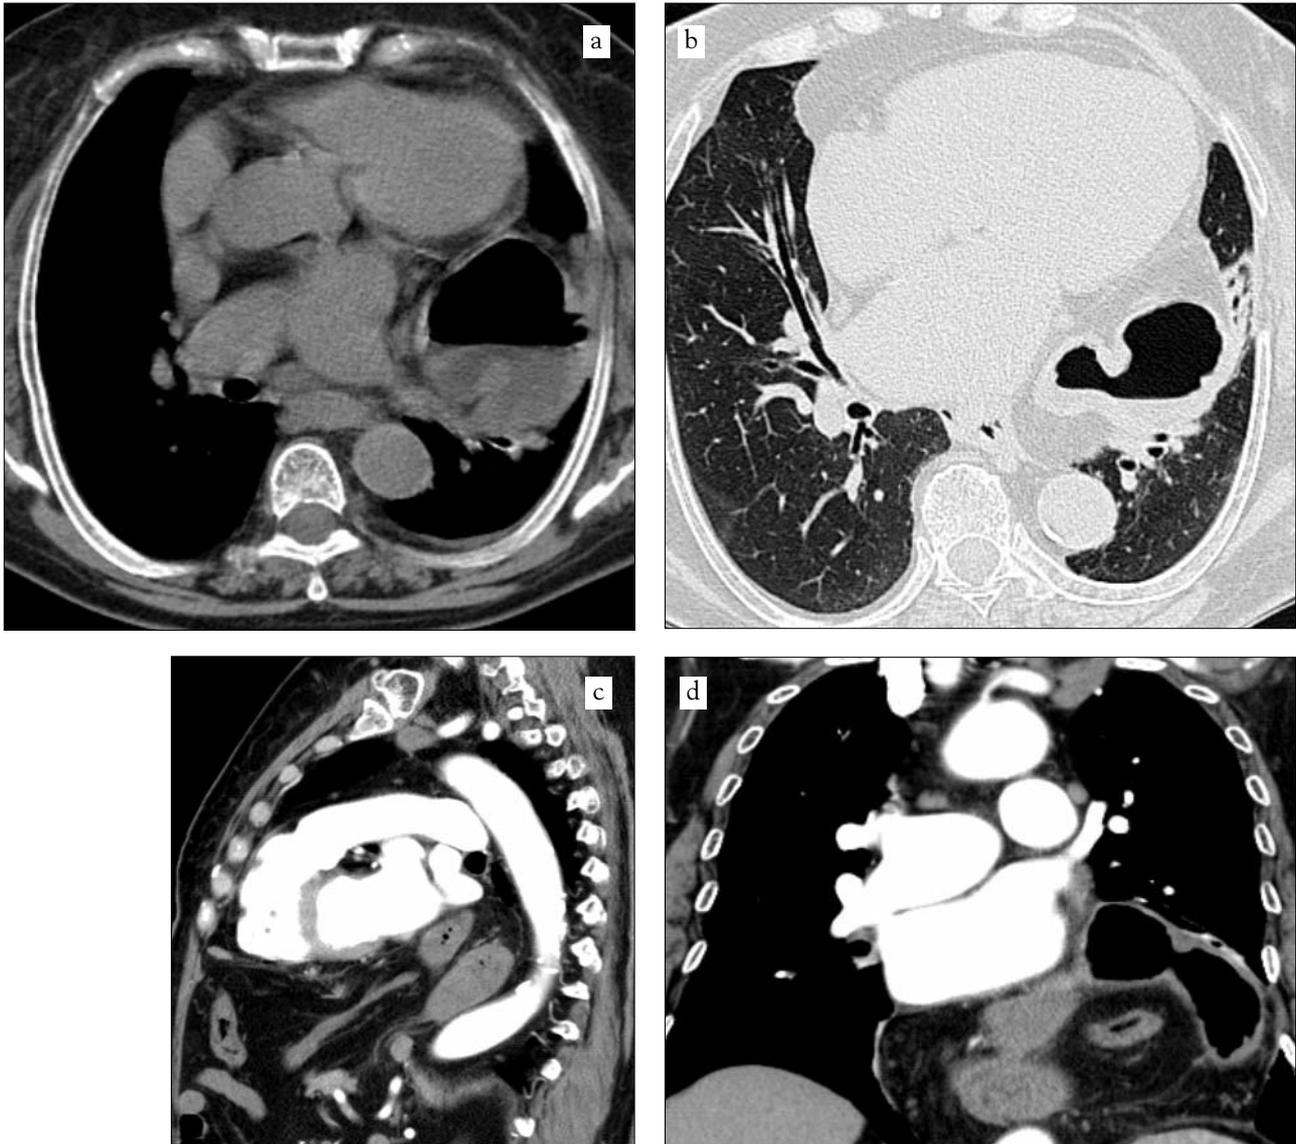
(a, b, c, d) CT scan: epigastric mass with air-fluid level on axial CT scan (a,b), stomach emerges into the chest next to oesophagus and the gastro-oesophageal junction remains in place on coronal sagittal plane (c,d).
